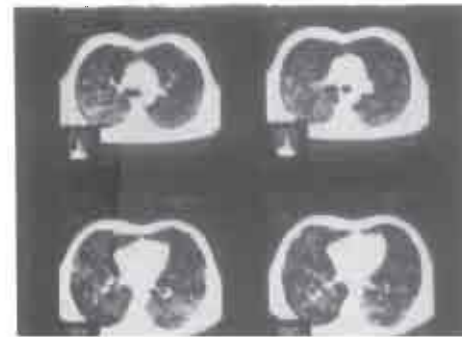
CT Scan, Thorax : Bilateral alveolar & interstitial opacities.
